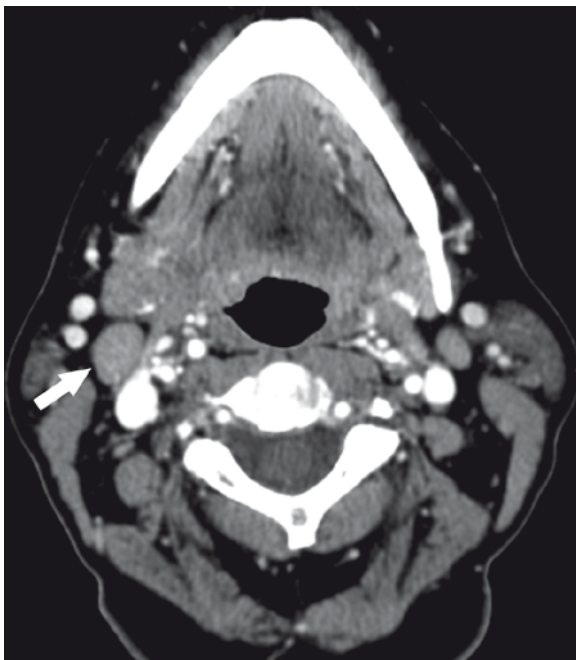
Right-sided retromolar trigone carcinoma with clinically N1 neck. Axial CT image shows a borderline enlarged (1.5 cm) right subdigastric node (*arrow*), which was presumed metastatic because of its location relative to the primary lesion as well as the clinical impression. At neck dissection, no tumor was found in this or any other neck node
